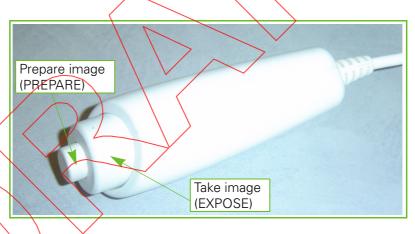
X-ray Console Hand-switch
